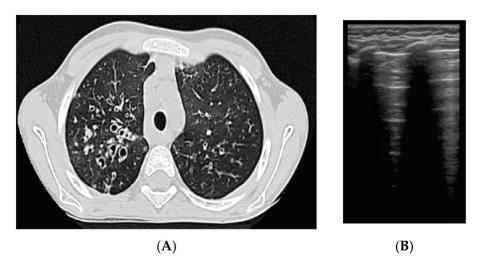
(A) LUS: coalescent B lines, erased A profile, loss of aeration, left hemithorax. (B) LUS image with subpleural consolidations, coalescent B lines, and left hemithorax. (C) CT scan of the same patients: (1) varicose bronchiectasis with middle 1/3 of lung extended and moderate bronchial wall thickening; (2) saccular bronchiectasis with mild and moderate wall thickening; and (3) zones with increased attenuation of pulmonary parenchyma (alveolar infiltrates).
